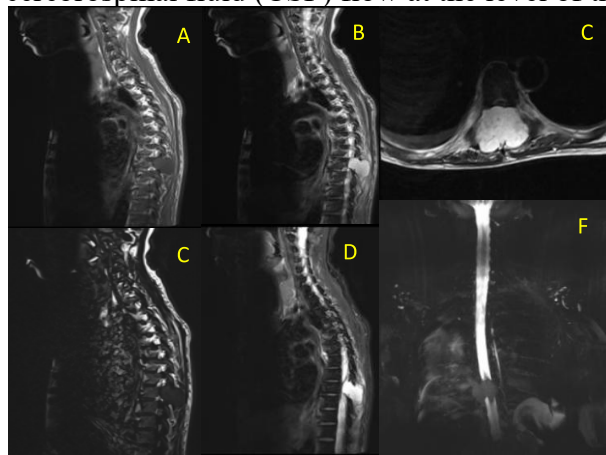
MRI Thoracolumbal sagittal and axial view show an extradural extramedullary mass at the posterior aspect of the vertebral bodies of T7–T9, extending into the epidural space, spinous processes, intradural space, and bilateral neural foramina. (A,C) The mass appears hypointense on T1WI/STIR, (B) hyperintense on T2-weighted images. (D) it show heterogeneous contrast enhancement. (E) Myelography show partial obstruction of cerebrospinal fluid (CSF) flow.
